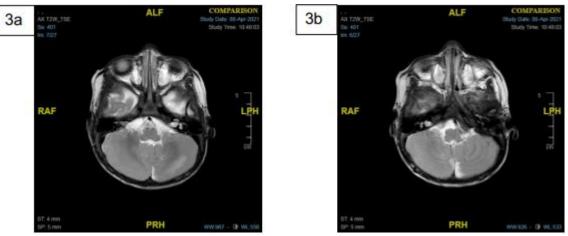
shows images of MRI T2 weighted Brain and Internal Auditory Meatus
